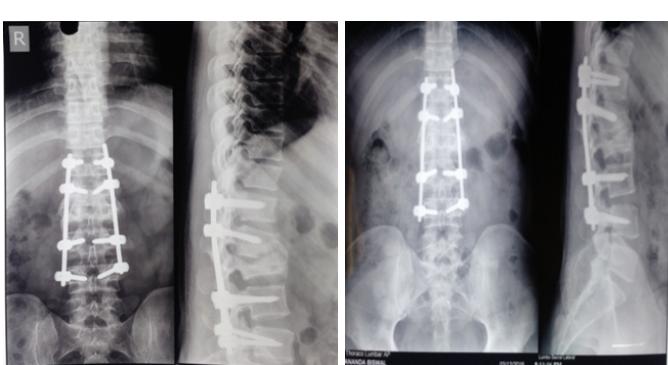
Postoperative X-ray, X-ray after 1 year showing complete fusion
